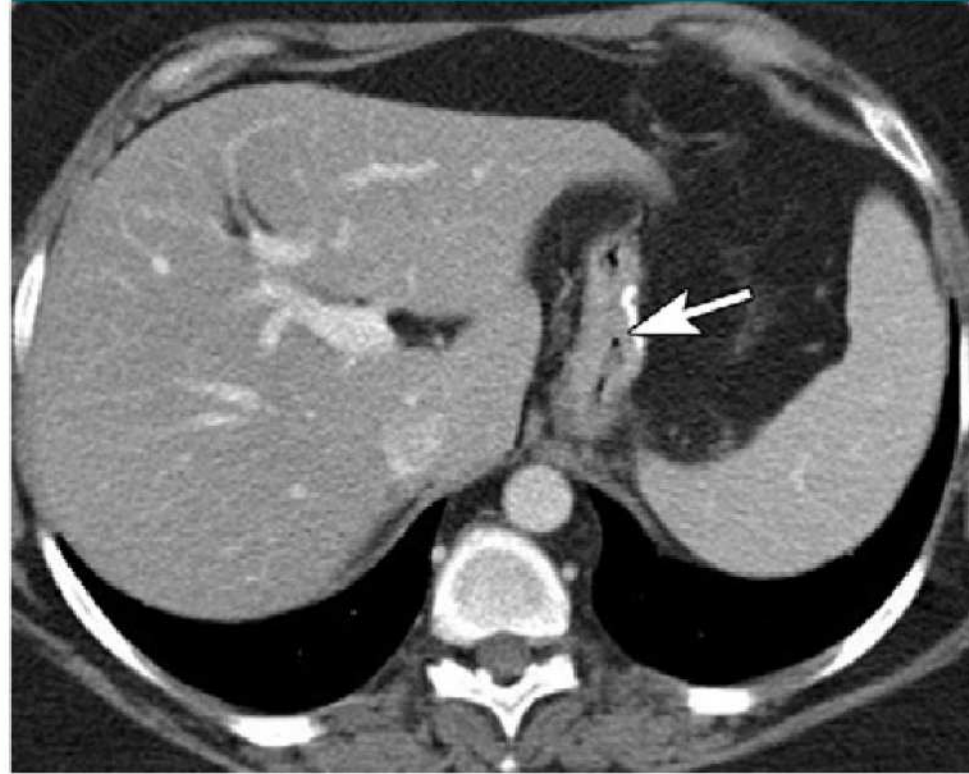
Normal appearance of sleeve gastrectomy at CT. Axial CT image after oral and intravenous contrast material administration show a small-caliber, tubular stomach after resection along greater curvature. Note surgical suture line (arrow). There is prominent fat attenuation in surgical bed.
